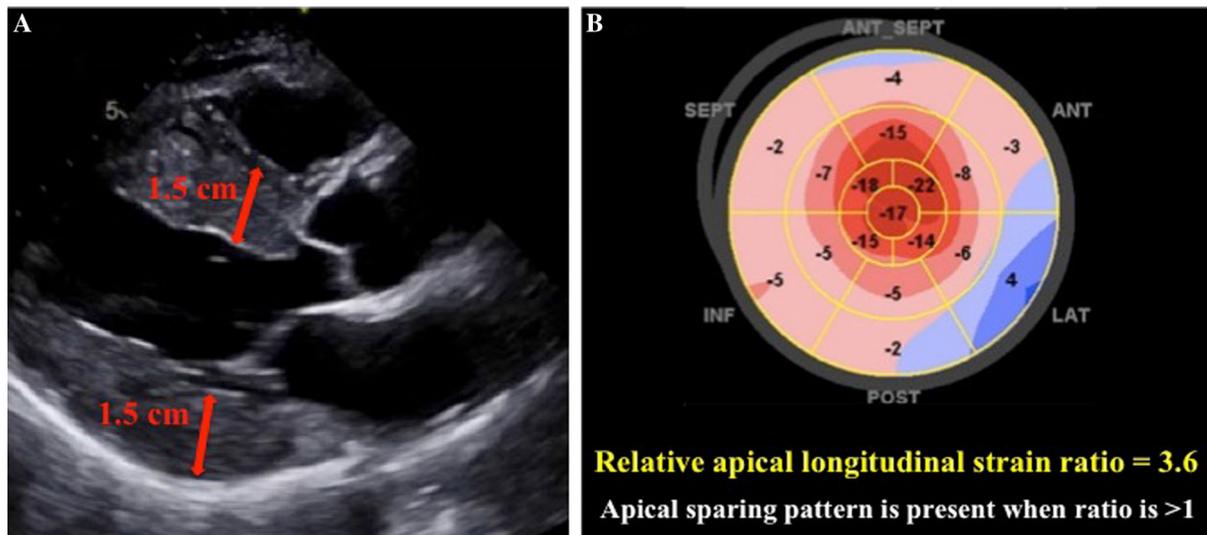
Transthoracic echocardiogram. A parasternal long axis view showing moderate concentric left ventricular hypertrophy (anteroseptal and inferolateral wall thicknesses at end-diastole of 1.5 cm each), and B 17-segment model of the left ventricle demonstrating apical sparing strain pattern on speckle tracking imaging. Apical sparing pattern (ASP) is calculated as a ratio of the average longitudinal strain of the 5 apical segments divided the average longitudinal strain of the 6 mid and 6 basal segments, and ASP is present when this ratio is > 1(1).
